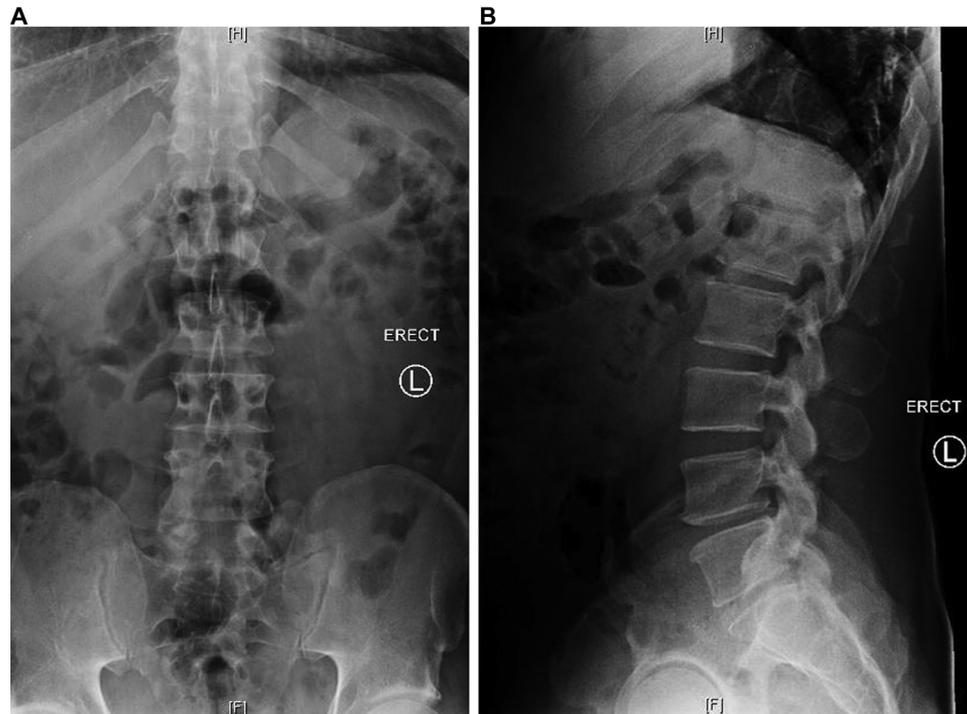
AP (A) and lateral (B) radiographs of a patient who previously underwent full laminectomy and right L4-L5 discectomy for cauda equina syndrome and right lower extremity radiculopathy, presenting with recurrent right leg pain 6 months postoperatively. Note disc space narrowing and facet arthropathy at L4-L5 with bony foraminal stenosis evident, without deformity.
